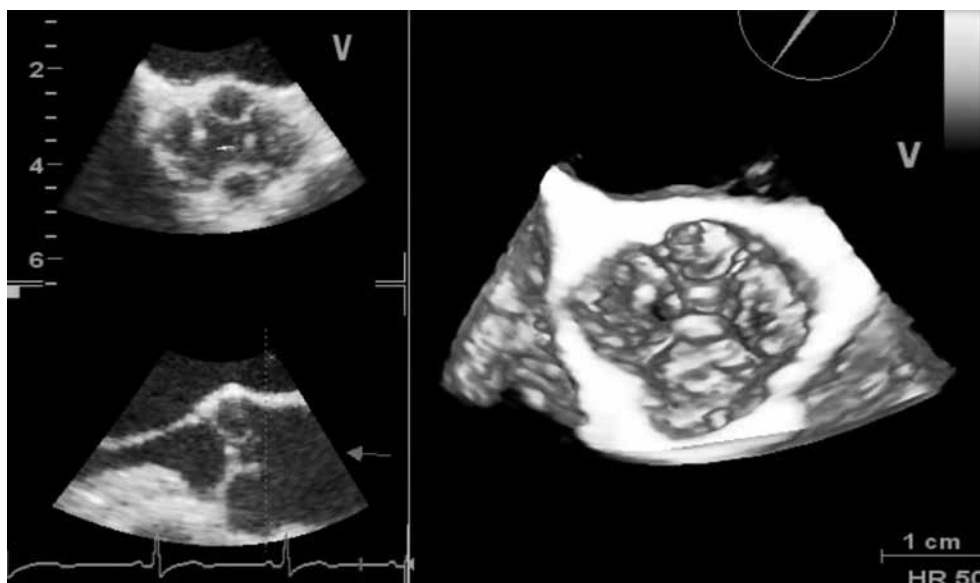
Intraoperative three-dimensional transesophageal echocardiography image showing quadricuspid aortic valve.
